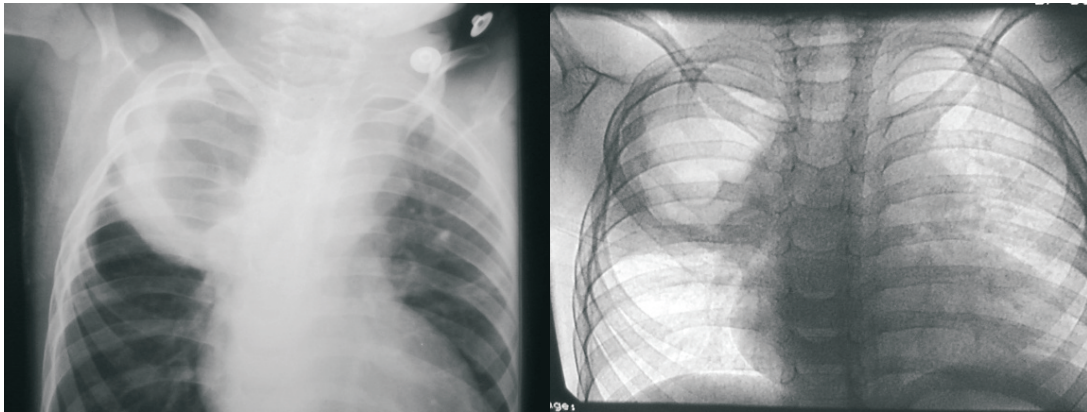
Post aspiration chest X-ray
